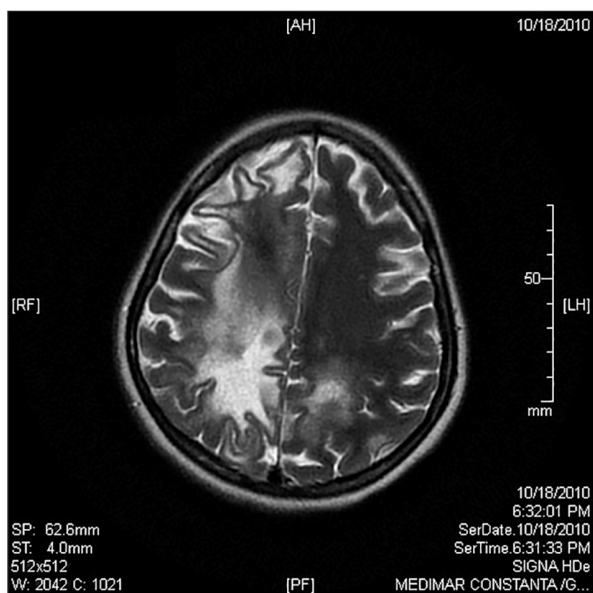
Cerebral MRI scan – hyperintense lesions on axial T2 weighted images; the lesions of the white matter are located fronto-parietal, bilateral and asymmetric
